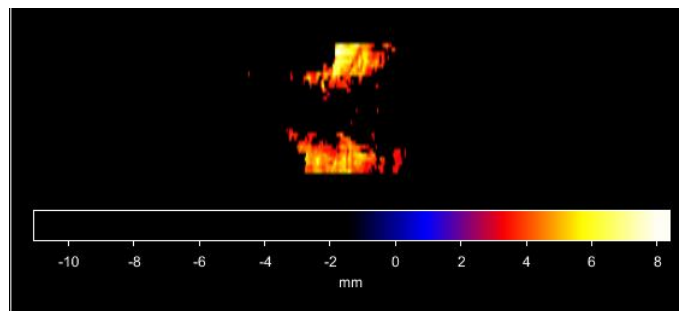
3: accWEPL difference map of the planning-CT and weekly-CT for the same patient as shown in figure 4.2
